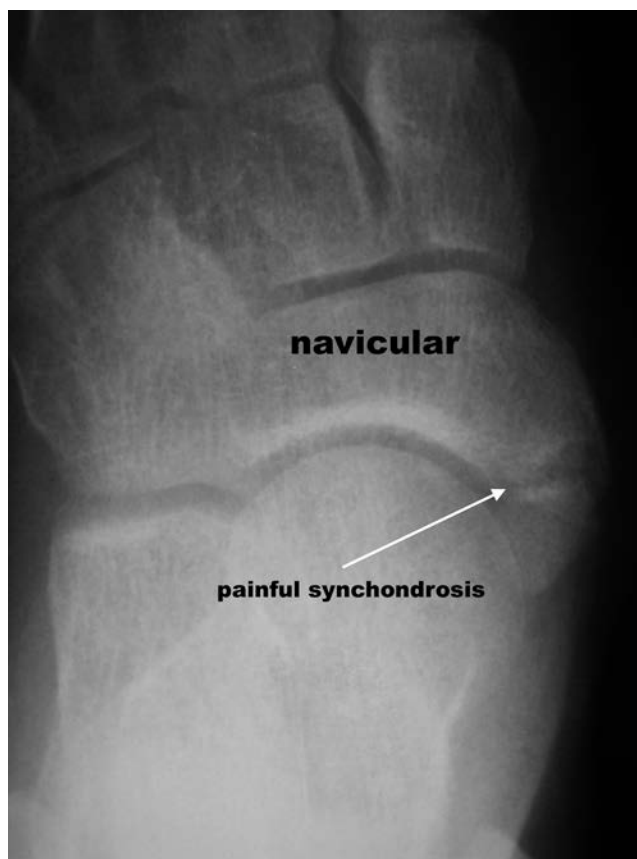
Anterior-posterior radiograph of athlete's foot depicting painful medial accessory navicular attached by synchondrosis.
